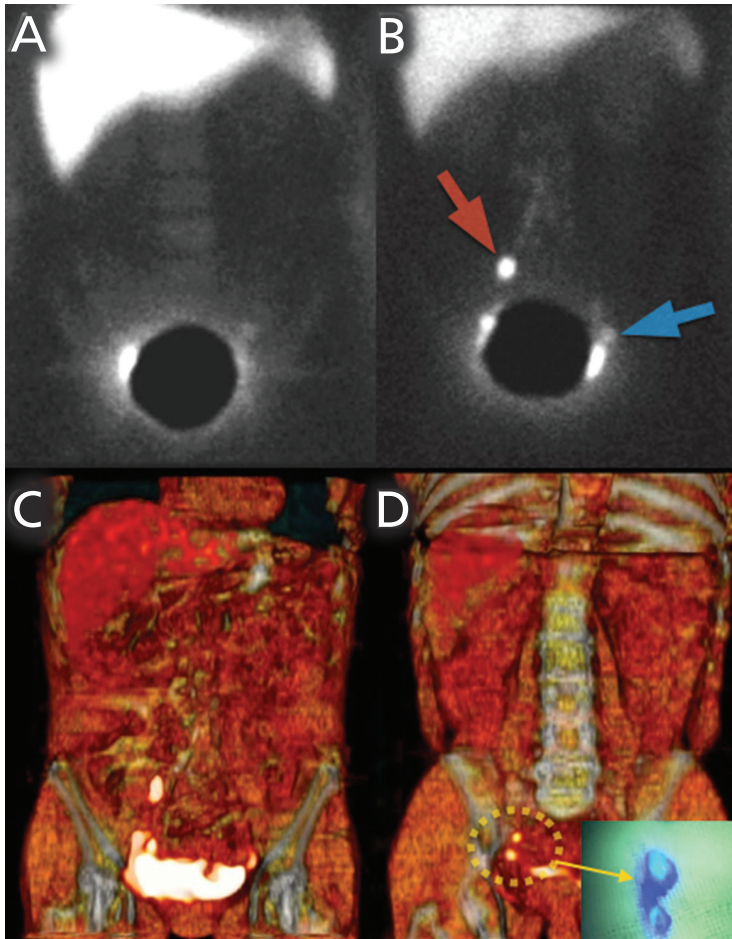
Endometrial cancer. Early planar image showed a very faint left node. A lead shield covered the injection area and high activity on the right side was supposed to be a partial zone of the injection area (A); delayed planar image displays a right sentinel node (red arrow) and the previously observed left sentinel node (blue arrow). 3D volume-rendering image shows the same node distribution like B (C); a more detailed analysis of SPECT/CT data and 3D reconstructed images showed two posterior and caudal nodes (dotted circle) previously to the marked as sentinel node in D corresponding to external iliac nodes during surgery (arrow).
